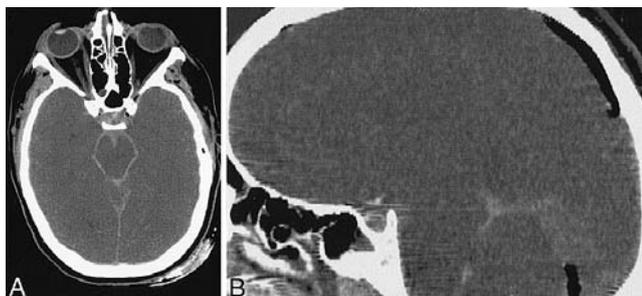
Unenhanced CT scans of the head. A: Axial view, revealing widespread SAH plus air in the cavernous sinuses. B: Sagittal reconstruction demonstrating air in the superior sagittal sinus and the straight sinus.
